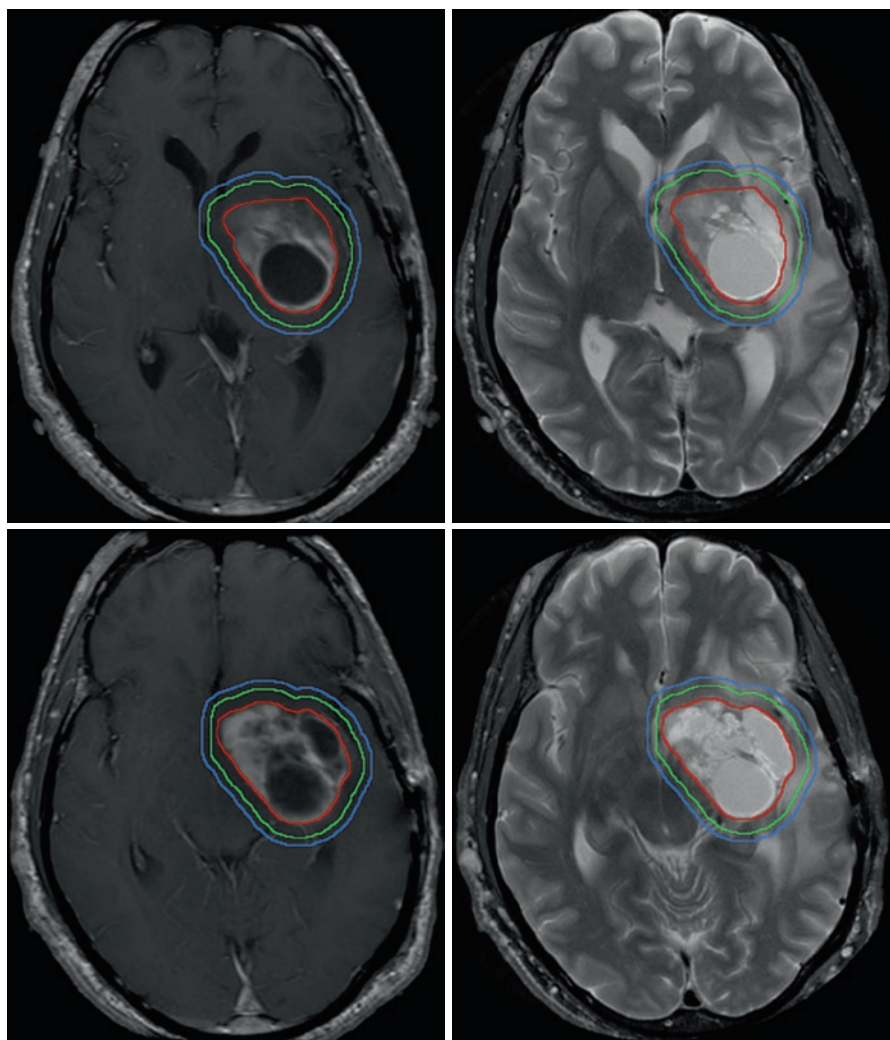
Juvenile pilocytic astrocytoma case. Axial T1 post-contrast images are shown on the left and axial T2-weighted images on the right. Red = GTV which includes both the enhancing disease and the tumor cysts. Green = CTV (GTV + 5 mm). Blue = PTV (CTV + 3 mm)
